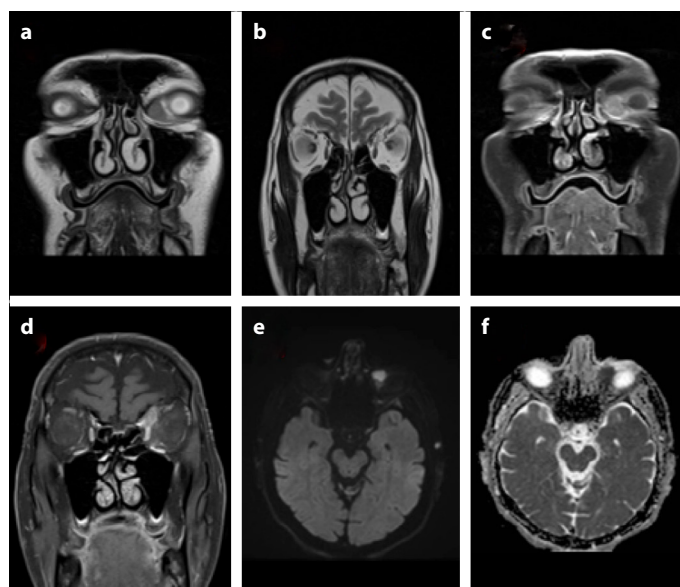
Magnetic resonance images of the tumor. (a and b) There are 2 hypointense solid lesions in the medial left orbit on T2-weighted images. (c and d) Intense contrast enhancement of the lesions was observed on contrast-enhanced fat-suppressed T1-weighted images. (e) Hyperintense in diffusion weighted imaging. (f) Apparent diffusion coefficient was also hypointense and diffusion restriction was observed.
